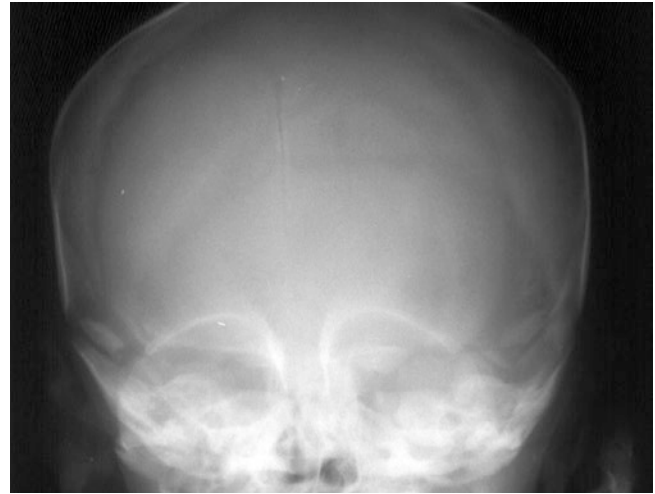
Frontal skull radiograph demonstrating hypotelorism due to premature fusion of the metopic suture
